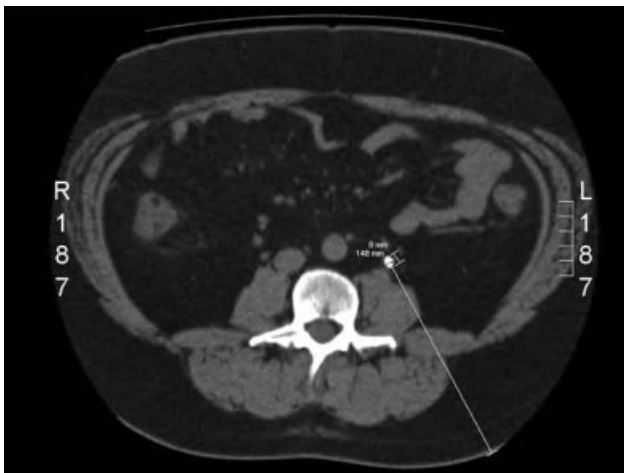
(A) Axial CT image of proximal ureteric stone with patient in a supine position. There is potential interference of shock waves from transverse processes of vertebrae. (B, C) Rotated-supine position. (D) Axial CT image
